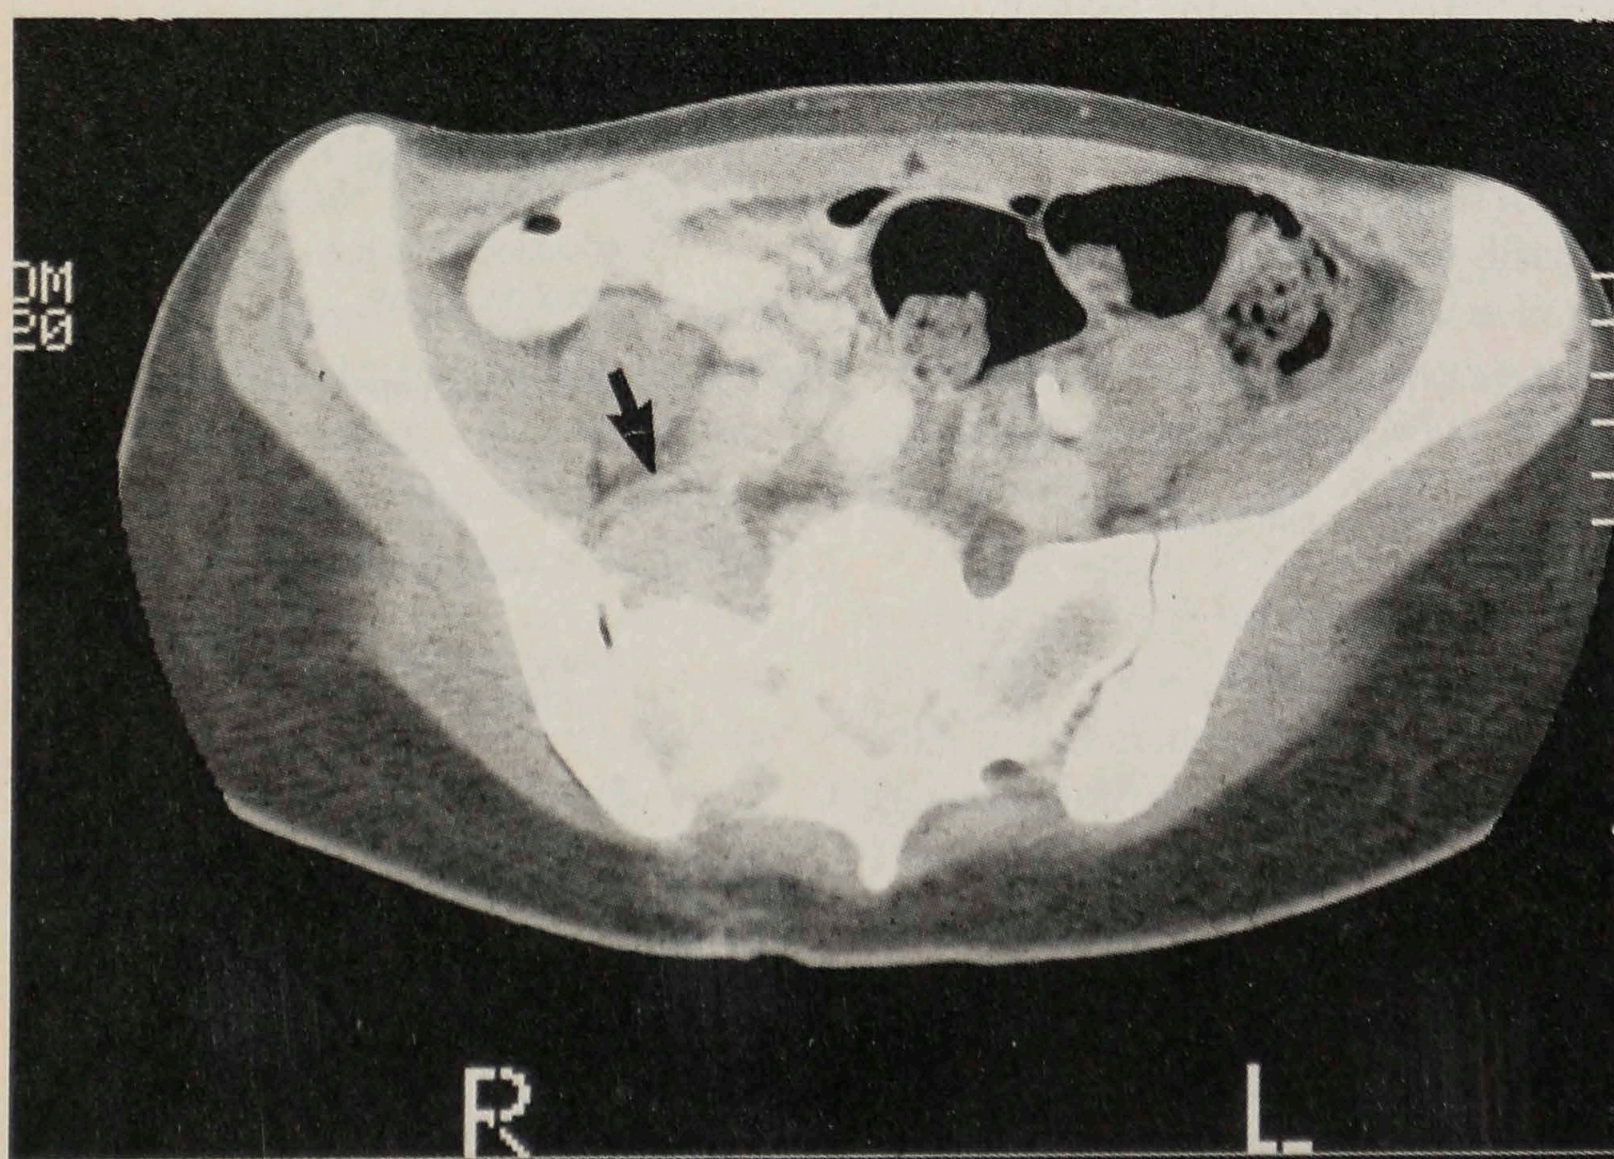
Computed tomography scan demonstrating large soft-tissue mass (arrow) extending from right sacrum that is in difficult location for biopsy.
